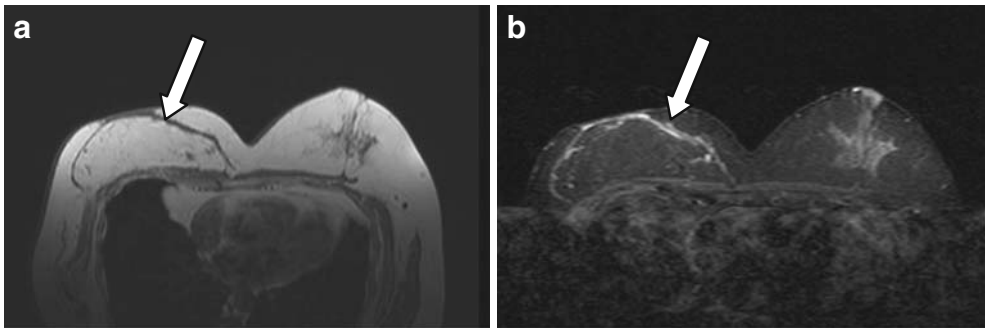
Case number 3131 of February 14th, 2005; 57 year-old patient, right mastectomy in 1997 and reconstruction with epiplon in 1997; T2-weighted sequences without fat suppression (A) and with fat suppression (B) in the transverse plan showing the reconstructed breast with epiplon (white arrows).
